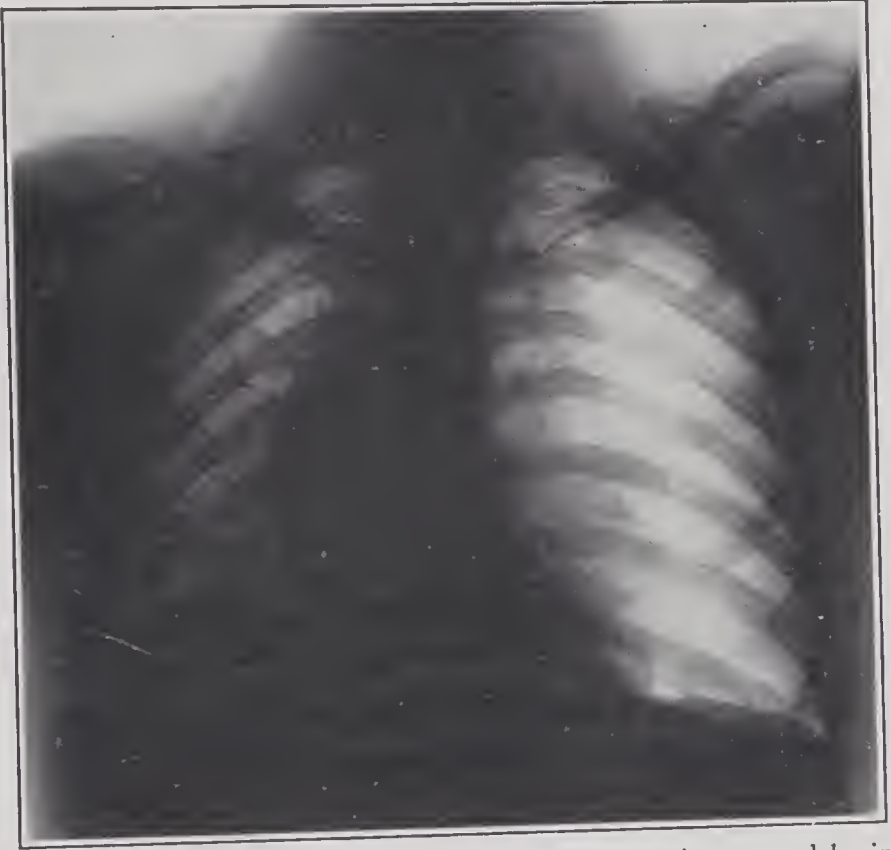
X-ray photograph of the chest of a tuberculous patient treated by introducing air into the right (as seen) pleural cavity (artificial pneumothorax). Note the outline of the collapsed lung on the right side near the middle of the air space. The diaphragm is markedly depressed and the chest wall bulged on the treated side. (Courtesy Roentgenology Staff, Billings Hospital.)
